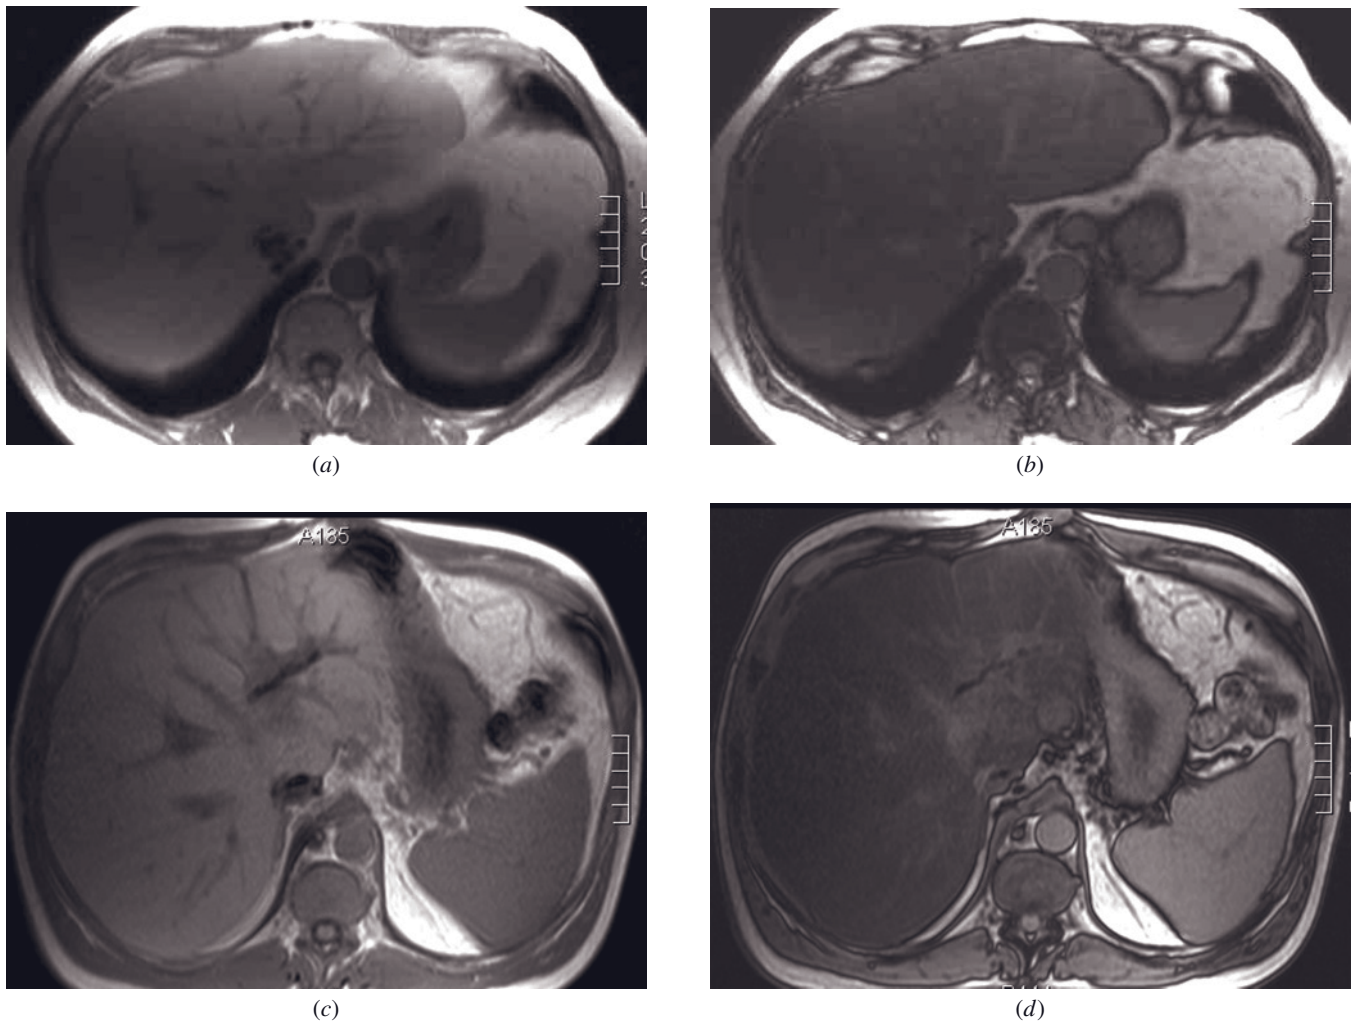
Fatty liver after transplantation. SGE (a, c) and out-of-phase SGE (b, d) images in two different patients after liver transplantation that demonstrate signal loss from in-phase T1-weighted images (a, c) to out-of-phase images (b, d) compatible with fatty liver.
